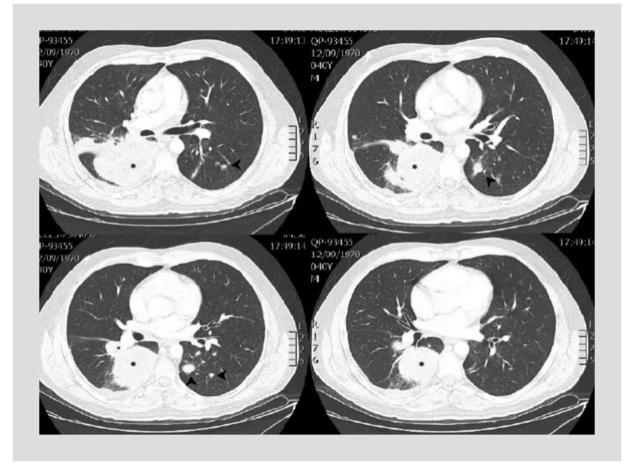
Pulmonary high-resolution CT. Ovoid-shaped (*), well-defined lesion with lobulated borders, located at the medial segment of right lung middle lobe, of heterogeneous density, with 120 x 82 mm diameter and attenuation values between 60 and 28 UH, same side pleural recess fluid occupation. At the level of the left pulmonary parenchyma, multiple hyperdense (arrowheads), amorphous images with spiculated borders, calcfiic density, are identified, the largest of 10 x 11 mm and the smallest of 5.5 mm in diameter; at lower lobe, stellate-appearing lesion, with pleural tail of 1.65 x 1.65 mm in diameter and attenuation values of 48 UH. Ovoid, hypodense right paratracheal lesions are identified with 19 x 10 mm and 17 x 10 mm dimensions in relation to adenopathies.
